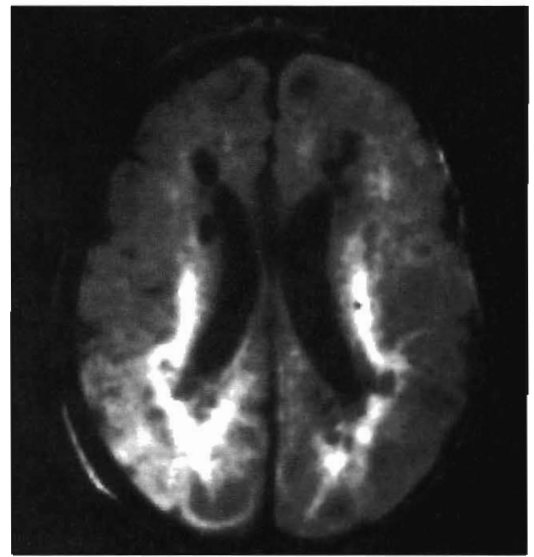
Periventricular leukomalacia. Axial fluid-attenuated inversion recovery (FLAIR) image obtained on a child with spastic diplegia and a history of prematurity and hypoxic episodes. Multifocal white matter hyperintensities, reduced white matter volume, irregular ventricular contours, and cystic changes are typical findings of periventricular leukomalacia.
